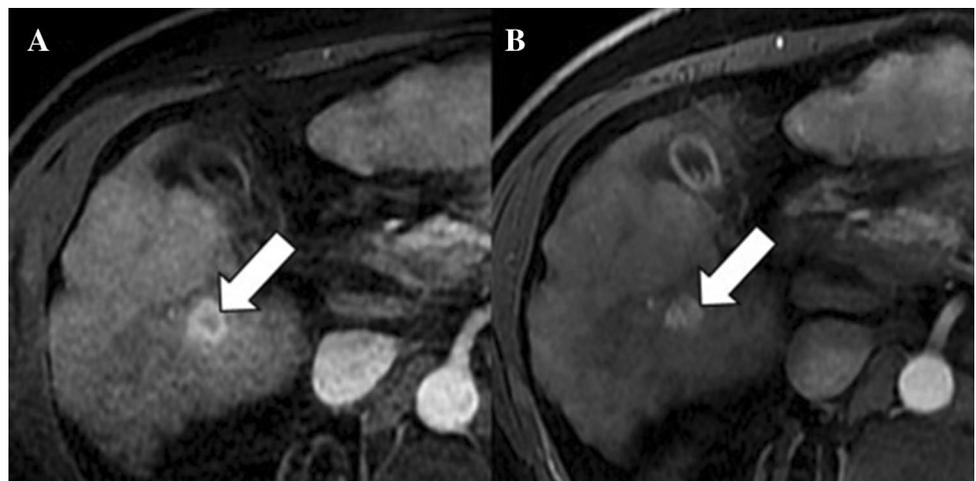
62-year-old man with NASH cirrhosis. a Baseline MRI on hepatic arterial phase shows a 1.6 cm lesion (arrow) in segment 6 with rim arterial phase hyperenhancement. At 3-month MRI follow-up (b) without interval treatment, the lesion demonstrates nonrim arterial phase hyperenhancement (arrow). The lesion was a pathologically proven HCC
